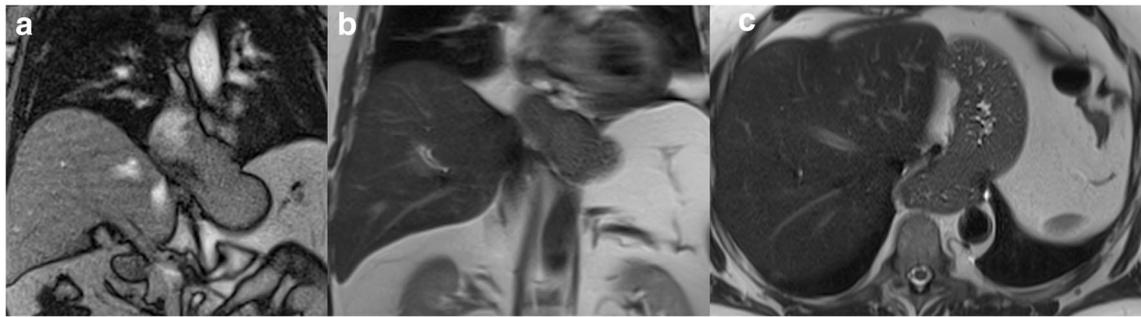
Hernia after wrap disruption. Comparison of real-time MRI (a) and HASTE in coronary and axial view (b and c). Images show complete disruption of the fundoplication wrap with herniation of a significant portion of the gastric fundus
